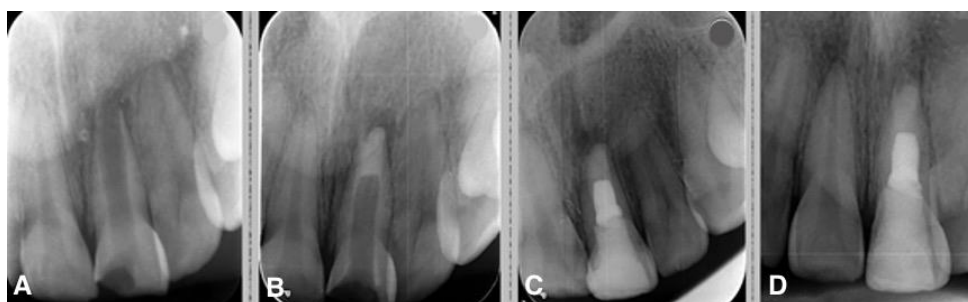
(A) Diagnostic X-ray of the immature left upper central with pulp necrosis as a result of trauma, (B) Creation of apical plug with MTA in the second session, (C) Root canal filling and cavity filling, (D) Control X-ray of the tooth 12 months later
